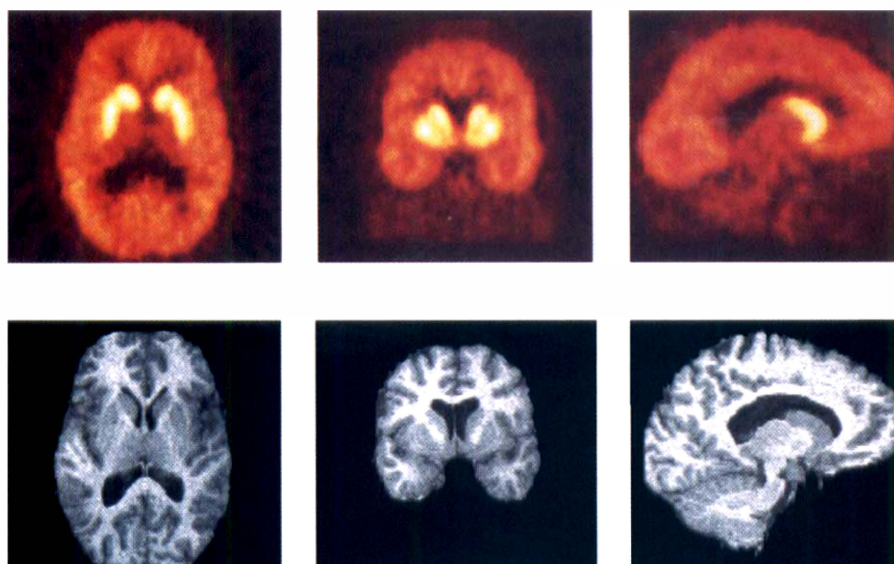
[^{11}C]NNC 112 in a human volunteer. (Top row) Positron emission tomography: Transaxial, coronal, and sagittal views of a 20-minute frame obtained 40 minutes after the injection of 16 mCi of [^{11}C]NNC 112 in a 22-year-old man. (Bottom row) Magnetic resonance imaging: SPGR (spoiled gradient-recalled acquisition in the steady state) acquisitions in the corresponding planes. Activity is concentrated in caudate, putamen, neocortex, and hippocampus. Background activity is measured in the cerebellum. Thalamic activity is very low. This distribution corresponds to the anatomical distribution of the dopamine D_1 receptors.
